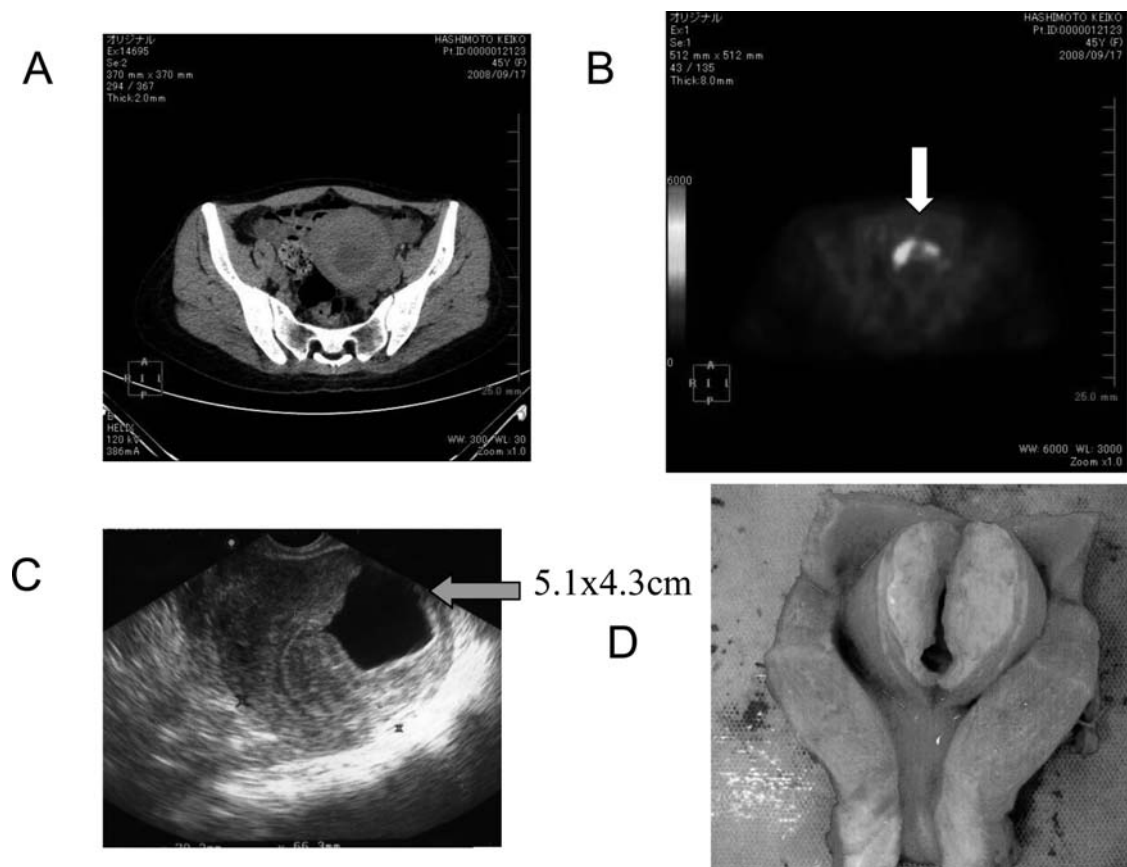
LM A case with an SUV of 3.99. (A) MRI, (B) PET-CT, (C) B-scope, (D) macro(adenomyoma). FDG uptake occurred around the cystic area.
